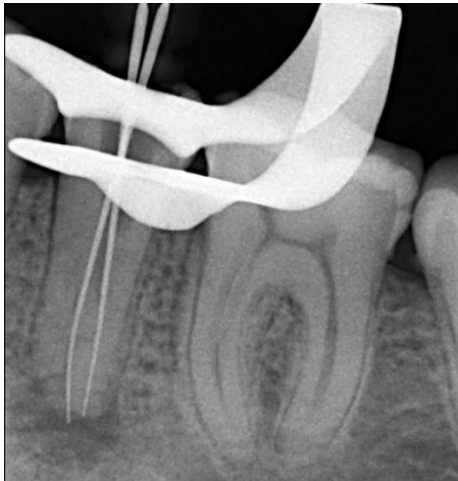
working length radiograph with ISO 15# K files placed in the canals (35) (Vertucci type IV)
